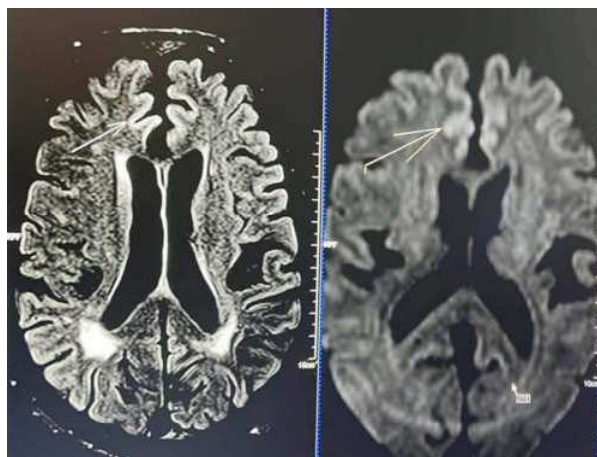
MRI Brain in which the arrow is showing Mild Gyriform Hyperintensity In Cingulate Gyrus.
